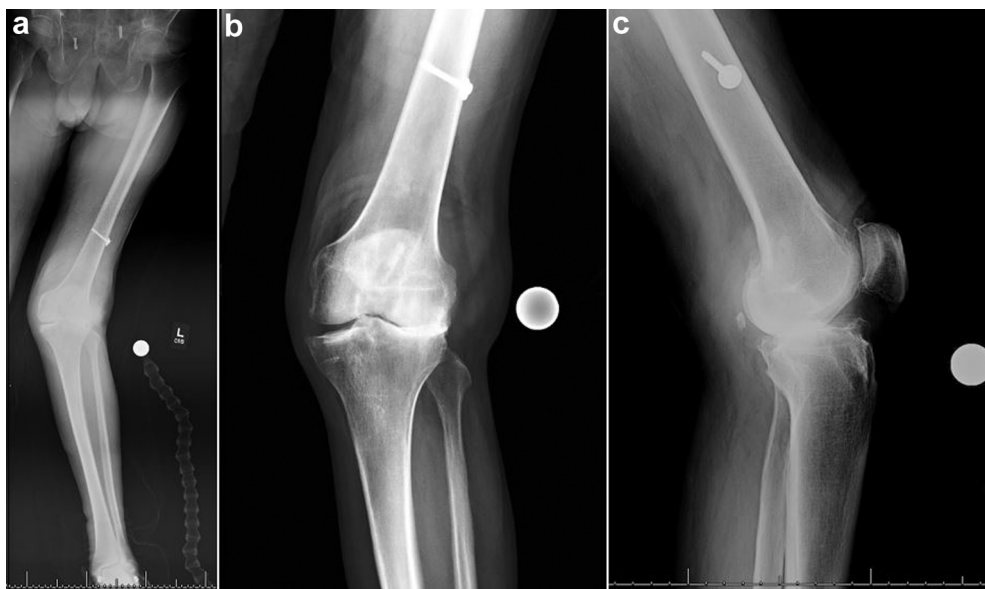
Prearthrodesis radiographs. PCA (a), anteroposterior (b), and lateral (c) radiographs showing valgus deformity and joint space narrowing after having recurrent MSSA septic knee arthritis.
